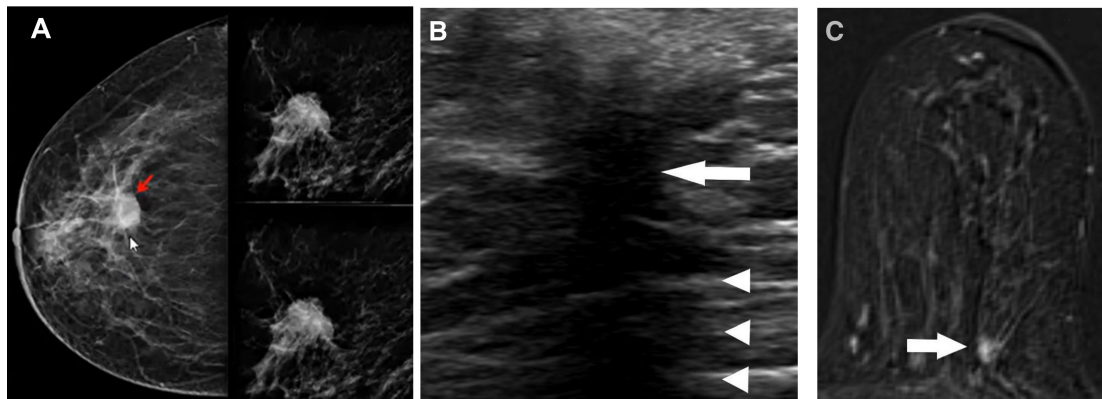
Imaging features of Luminal A subtype. A) Mammography shows a mass with spiculated margin, B) US shows hypo-echoic mass with posterior acoustic shadow, and C) MRI shows an irregular enhancing with spiculated mass.
